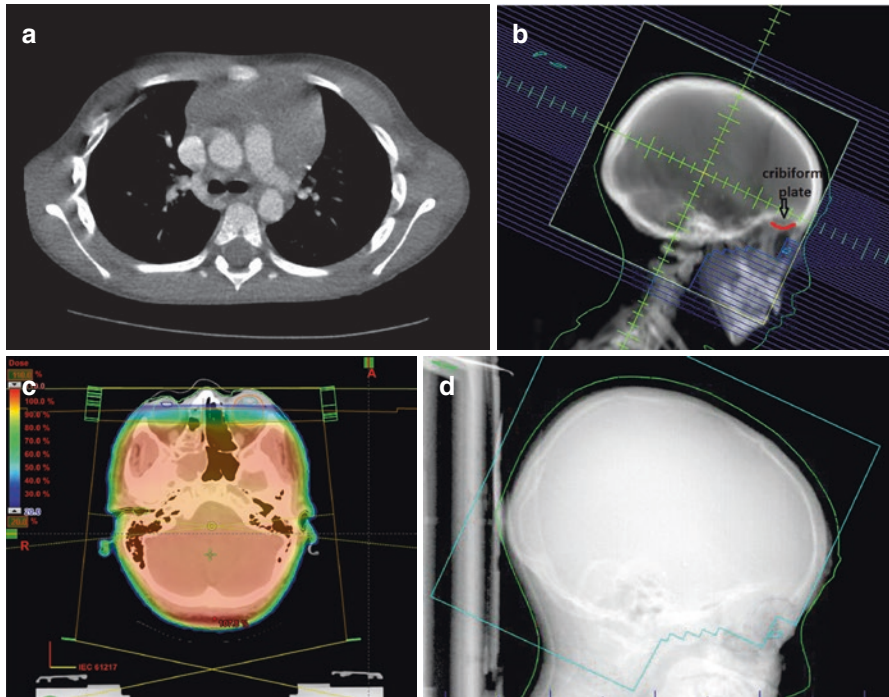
Example of cranial RT fields for leukemia. A 6-year-old male presented with a petechial rash from thrombocytopenia along with anemia and a white blood cell count of 115,000. Chest CT scan showed an 8 cm mediastinal mass. Peripheral smear and flow cytometry showed a T-cell acute lymphoblastic leukemia. Lumbar puncture did not show any evidence of lymphoblasts though there were a few mononuclear cells. After being placed into complete remission with induction chemotherapy, the patient received cranial RT to 12 Gy in 8 fractions during consolidation phase of therapy. Standard lateral fields to the whole brain through C2 was set up with blocking and gantry angles to align the divergence of the anterior edge of the fields, so as to reduce dose to the anterior eye and lenses. There was attention in the field design to cover the cribriform plate and posterior eye. Three years later, the patient remains in remission as he is finishing up maintenance therapy. Panel (a) shows the presenting chest CT. Panel (b) is the digitally reconstructed radiograph with multileaf collimation of field edge blocking the face and anterior eye. The cribriform plate is outlined. Panel (c) shows the dosimetry at the level of the eye. Panel (d) is a port film of the patient's first fraction of radiotherapy
